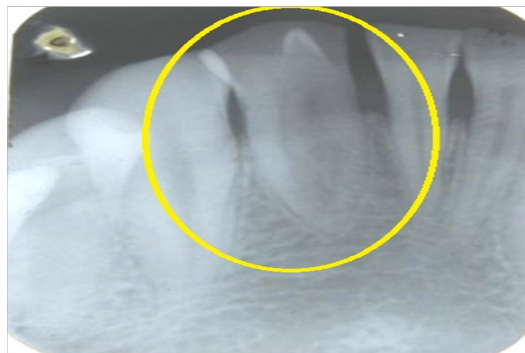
Intra-oral periapical radiograph of the specific region (encircled)
